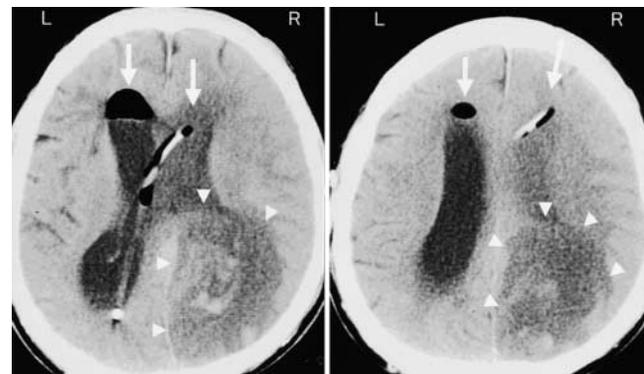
Postoperative CT scans of the brain demonstrating the draining catheter penetrating the ependyma of the right anterior horn, with the tip in the left posterior horn. There is no air in the tip in the left posterior horn, except that inside the catheter (left arrow on each scan), although there is some air in the left anterior horn (right arrow on each scan). Arrowheads mark the boundaries of large right occipital infarction.
